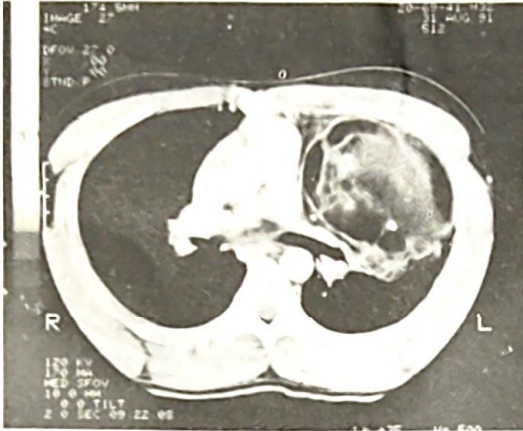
(Case 2): CT scan of chest showing a mass continuous with the pericardium on the left and containing mixed tissues of fatty, calcific and soft tissue densities.
